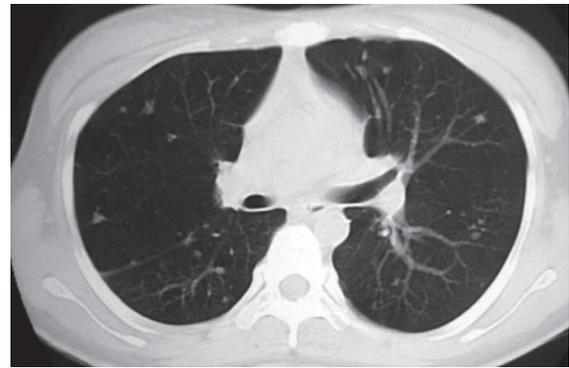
Chest CT scan showing multiple pulmonary nodules in both lungs.
